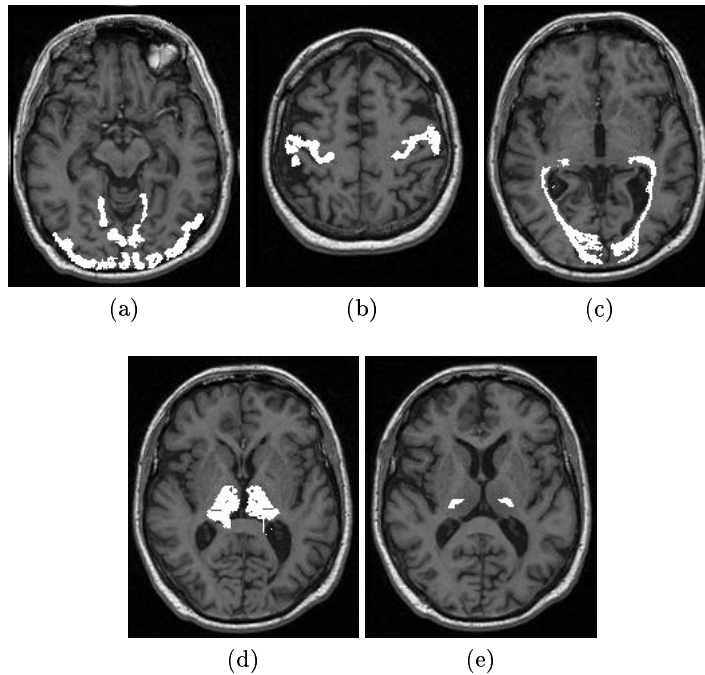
Overlay of selected critical structures on the MRI images. The structures were determined by spatially transforming the Talairach atlas into registration with the MR image. (a) Brodman areas 17-19 (b) Brodman areas 1-4, (c) Optic radiations, (d) Thalamus, (e) VPL nucleus (the target).
